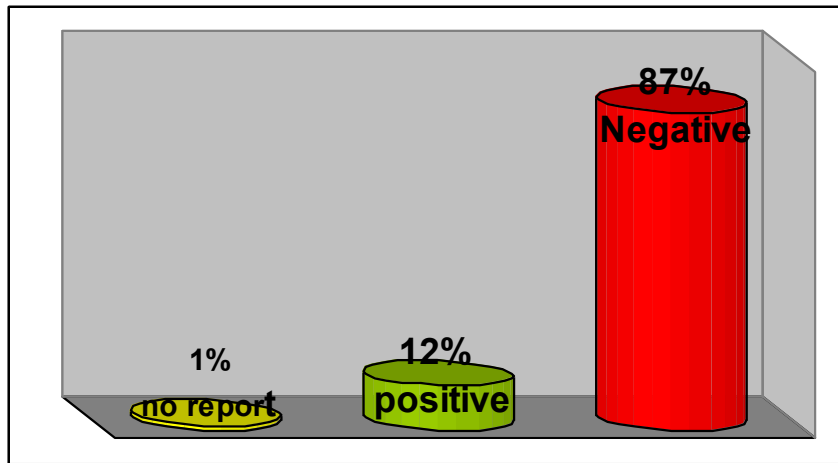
4) Distribution of non urgent brain CT scan examinations according of result in neurology department
